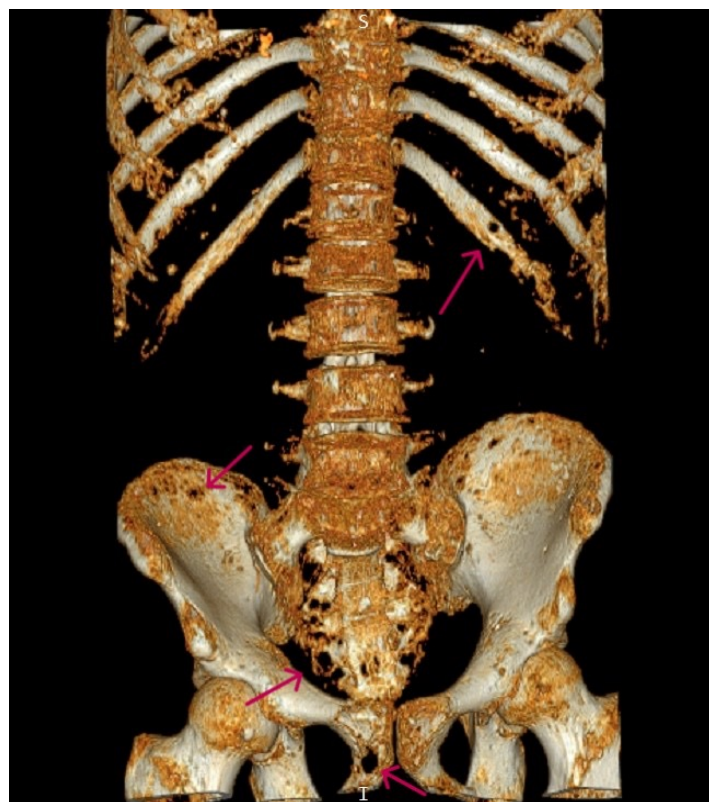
Thoraco-lumbar spinal CT scan. Volumetric view. Multiples osteolytic lesions in ribs, sacral and pelvic bone. (red arrows)
